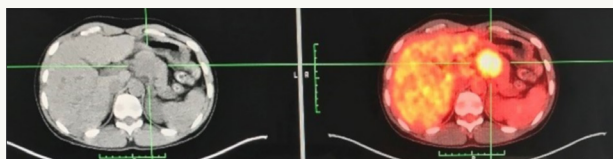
Positron emission tomography (PET) scanning showed the nodule of the pancreas body with SUV 5,8
